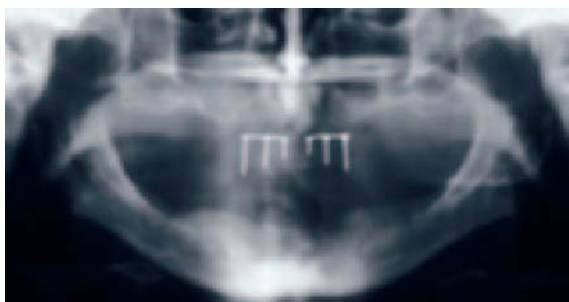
Panoramic radiograph showing an extremely resorbed upper jaw.
